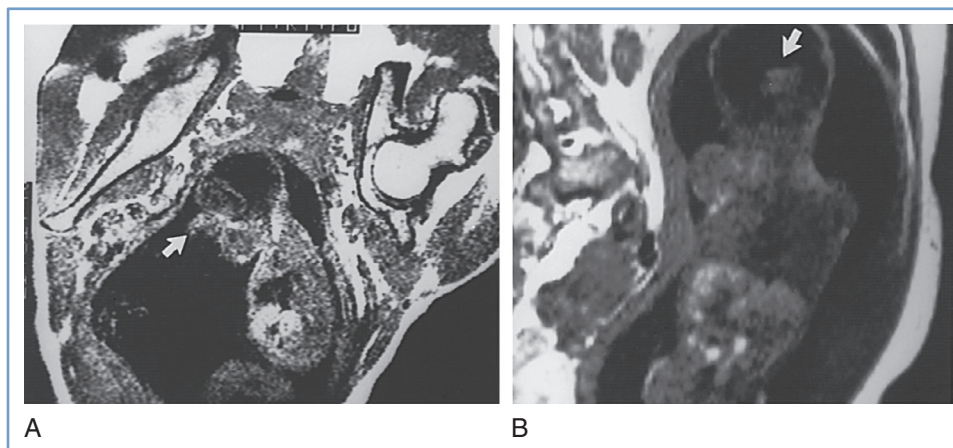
■ Magnetic resonance images of a fetus with holoprosencephaly. A, Sagittal view showing the proboscis (arrow). B, Coronal view showing the single ventricle and fused thalami (arrow). (Reprinted from Wenstrom KD, Williamson RA, Weiner CP, et al. Magnetic resonance imaging of fetuses with intracranial defects. *Obstet Gynecol* 1991; 77:529-32.)
